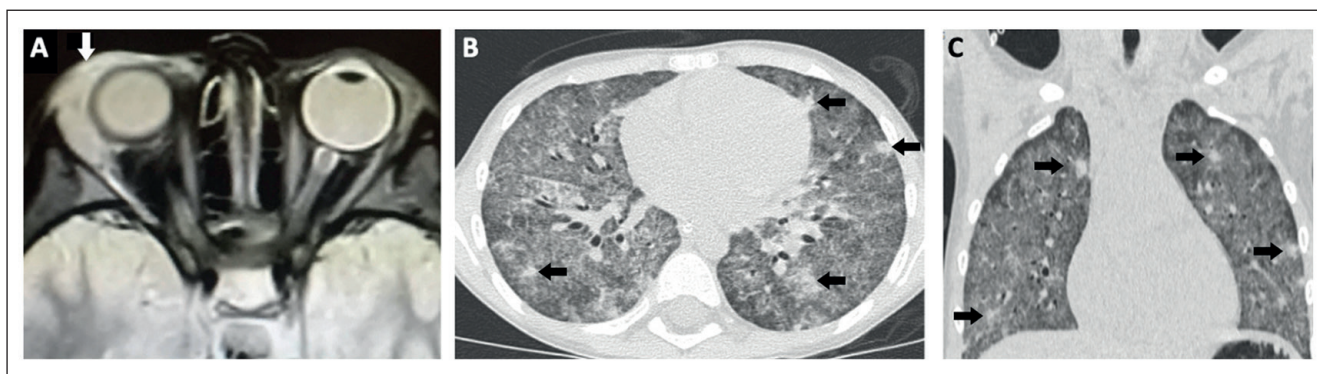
Case 3. A) Orbital magnetic resonance imaging (MRI): Extensive infiltrative bilateral orbital process, with predominant involvement of the right orbit, with compromise of the lachrymal glands and superolateral bilateral intraorbital adipose tissue of both orbits. (White arrow). B y C) Pulmonary computerized tomography (CT): Diffuse ground glass opacities, multiple diffuse nodules, with some predominantly excavated in the upper lobes (Black arrows).
